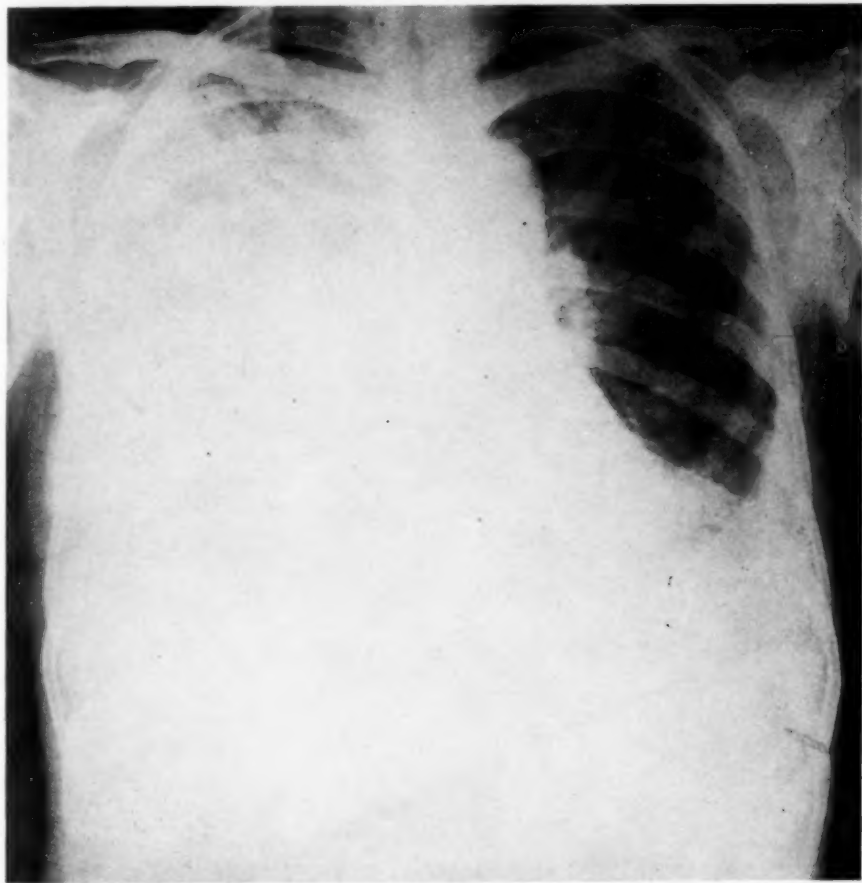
Roentgenogram of chest one month preoperatively.
